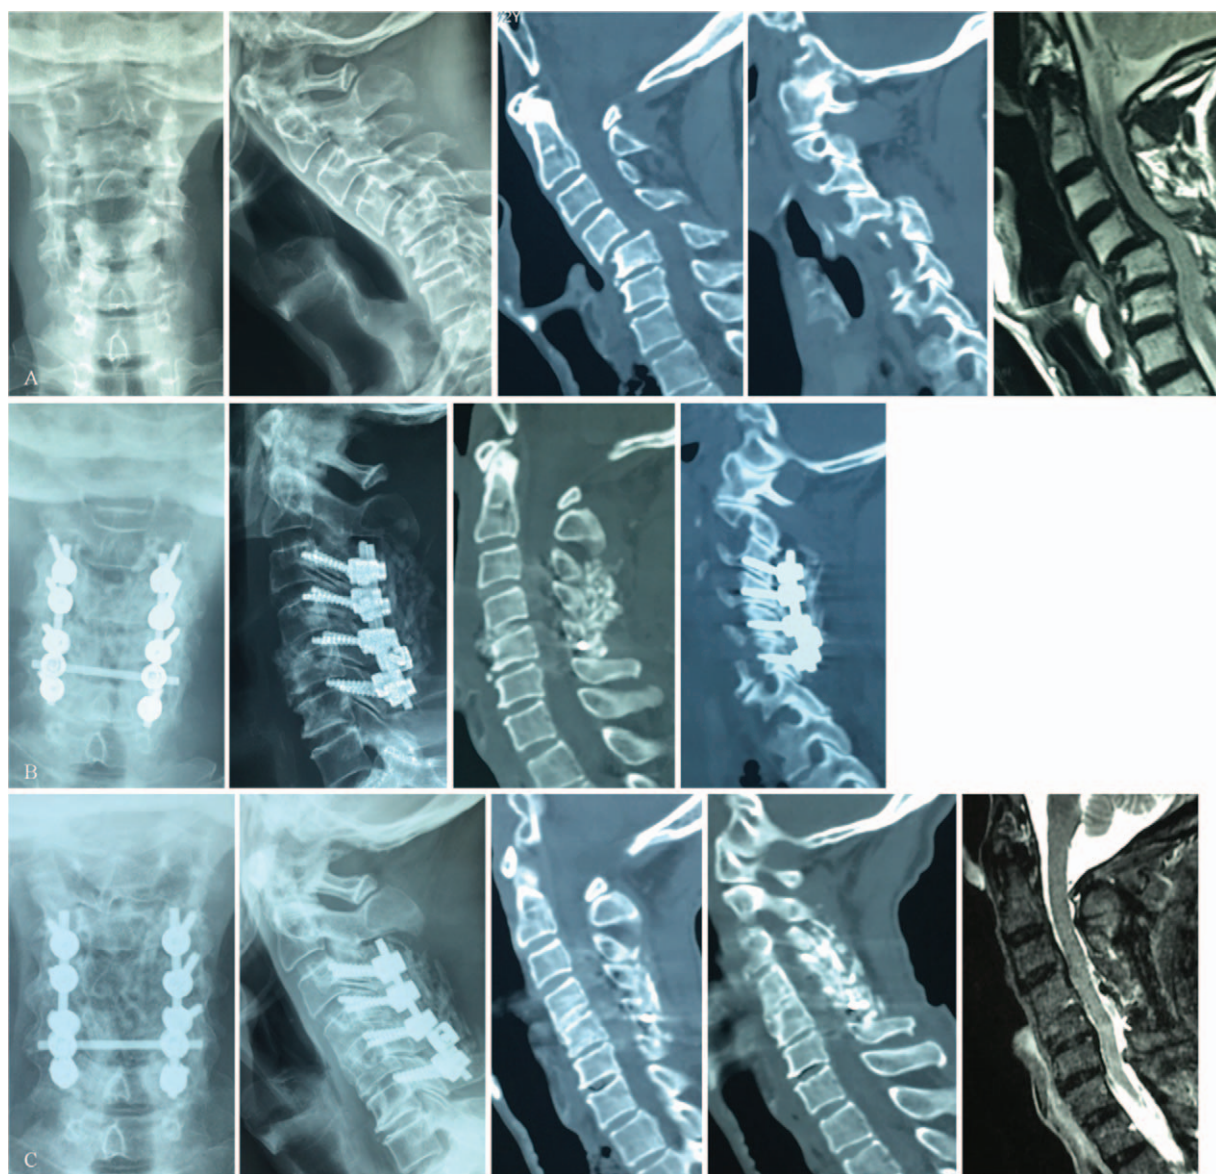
A 72-year-old male patient suffered from a fall injury. The diagnosis was delayed for 8 months because he just had mild neck pain after the accident. (A) Preoperative radiographs and sagittal reconstruction CT demonstrated C4–C5 dislocation with bilateral locked facets and remodeling of the facets. The MRI indicated obvious compression of the spinal cord. (B) At 1 week after surgery, radiographs and CT images showed perfect restoration of the dislocated segments and adequate amount of bone graft. (C) At 15 months of follow-up, the radiographs and CT images confirmed the anterior and posterior fusion. The CT and MRI images revealed enlarged spinal canal at C4–C5 level. CT=computed tomography, MRI=magnetic resonance imaging.
